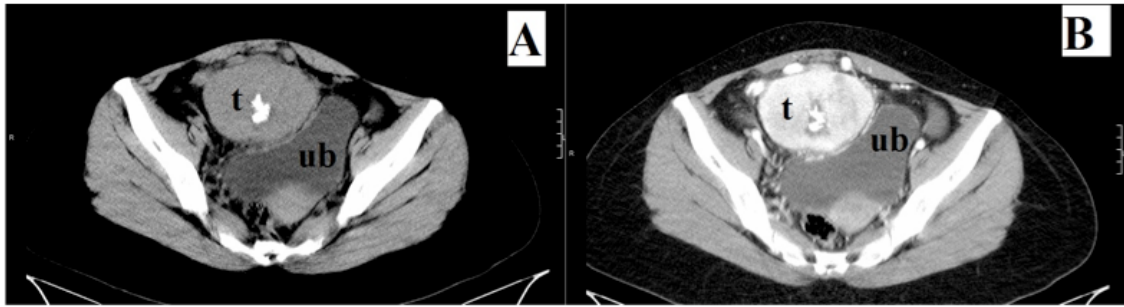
CT image through the pelvis (A). Contrast-enhanced image; note tumor's vascular-supply and central calcification (B). "t": tumor. "ub": urinary bladder.
